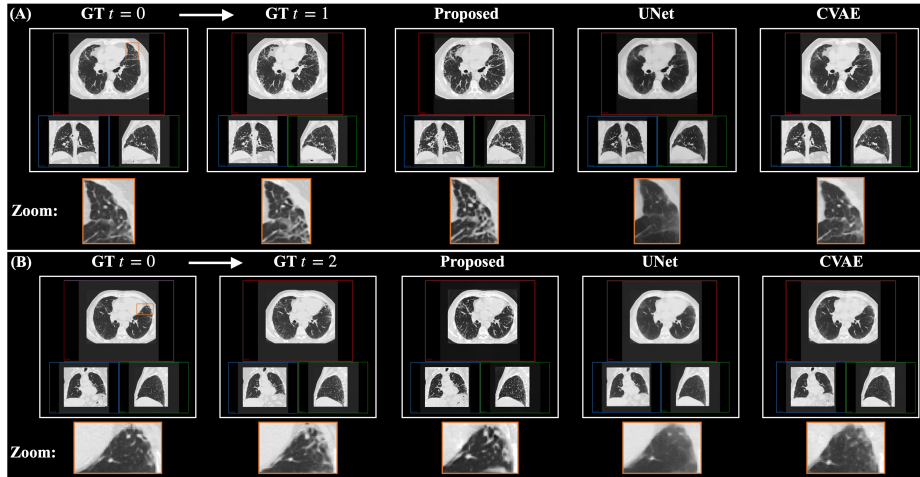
Qualitative longitudinal thoracic CT synthesis. Two representative patient cases (A–B) are shown with baseline (GT $t = 0$), ground-truth follow-up (GT $t = 1$ or $t = 2$ years), and generated follow-up scans from *Proposed*, latent U-Net, and latent cVAE. Axial/coronal/sagittal views and zoomed regions highlight local parenchymal progression patterns.
